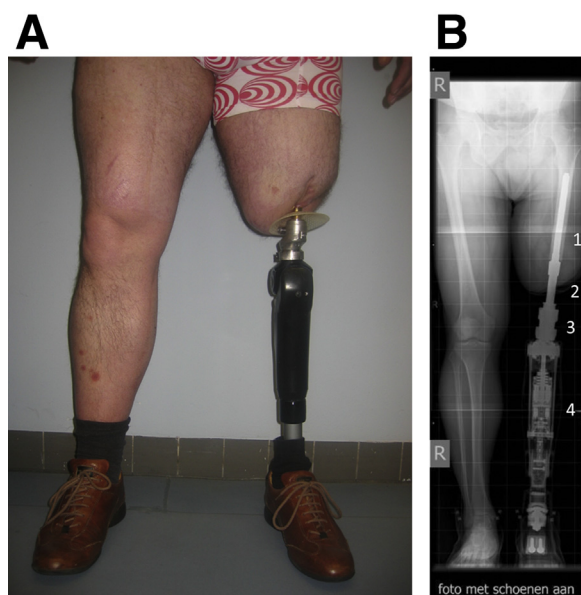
(A) Frontal view of subject with OIP. (B) Radiograph of a subject with OIP: 1, intramedullary implant; 2, transcutaneous unit; 3, click-safety adapter; 4, microprocessor-controlled prosthesis. The subject in A is not the same as the subject in B.
